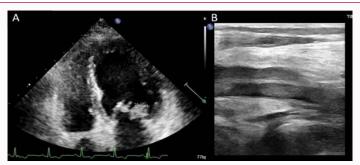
Transthoracic echocardiography and Lower limb arterial ultrasound on presentation. (A) Transthoracic echocardiography on presentation. (B) Lower limb arterial ultrasound on presentation.
